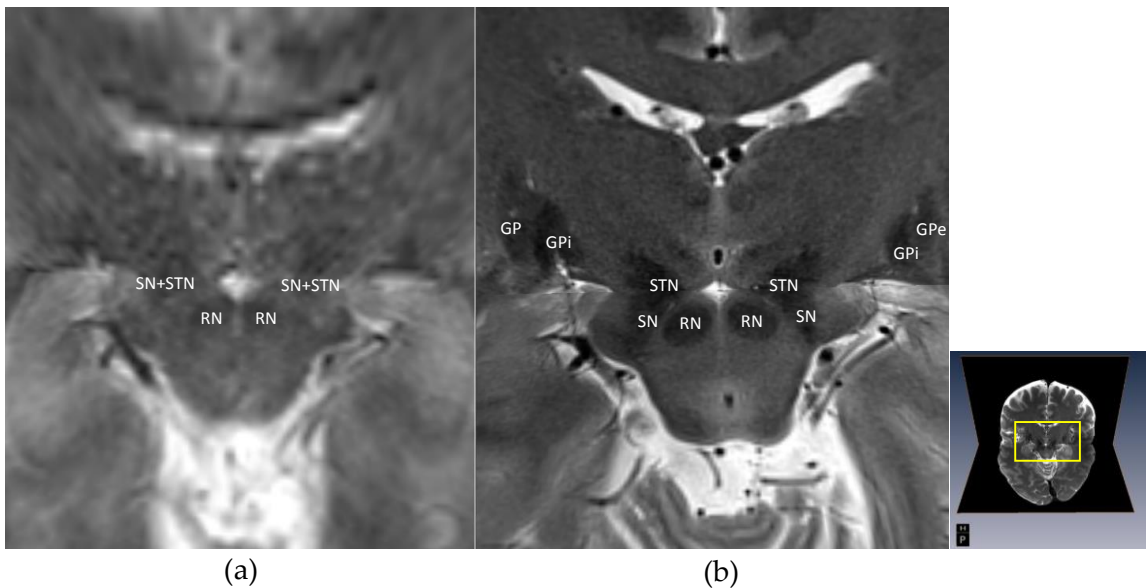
Visual comparison of brain sub-cortical structures - SN, STN, RN, and GP regions - from (a) the 1.5T (current practice) and (b) 7T T₂W MRI (registered onto the 1.5T pair) in the axial and coronal plane.
